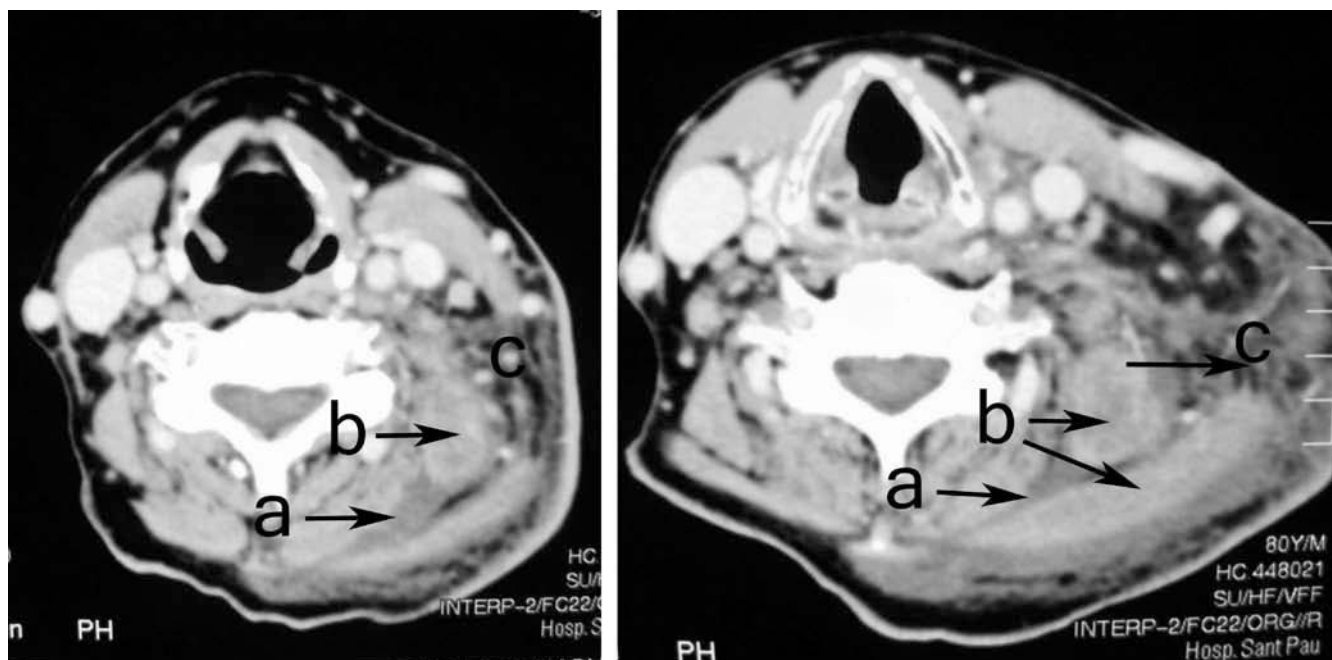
Preoperative CT images. Important asymmetry at the expense of the left posterior musculature where a collection of perifascial fluid can be observed (a), muscular oedema, intramuscular necrosis (b) and adjacent cellulitis (c).
